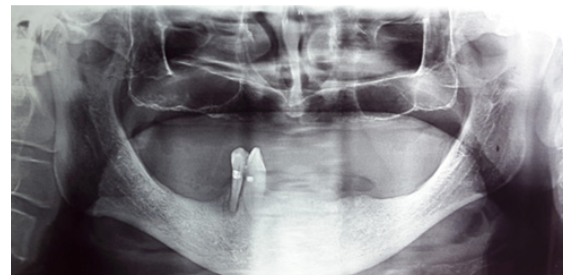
Periapical radiolucency in dental piece 44.
